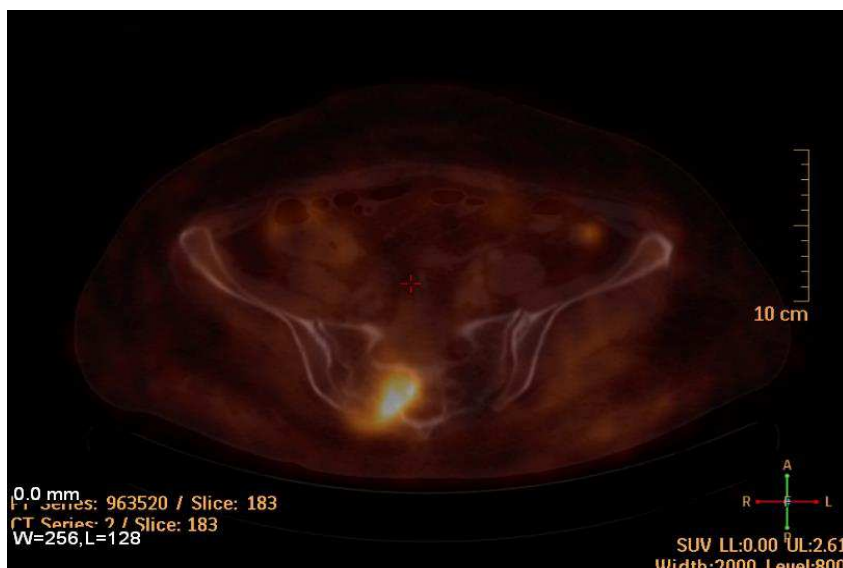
An enlarged PET/CT image is a metastasis in the right lateral mass of the sacrum
